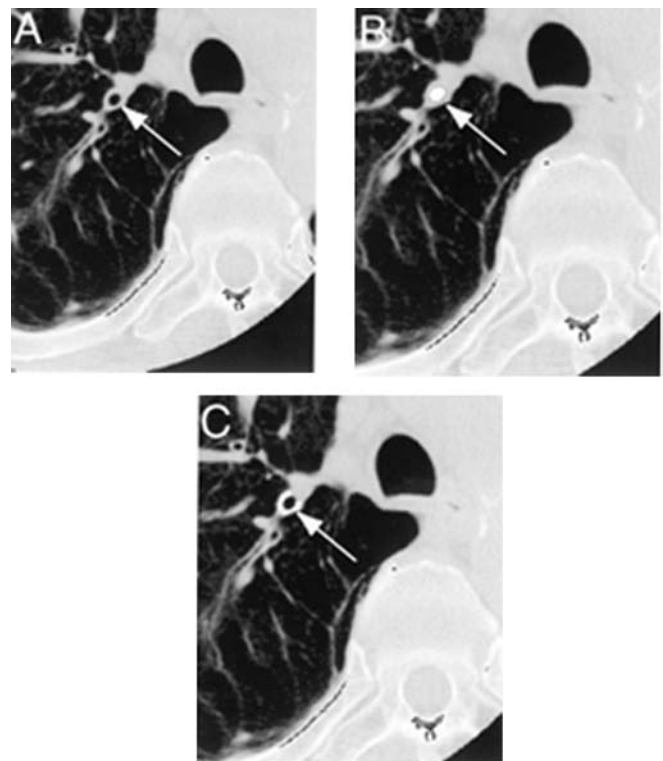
A representative case showing the process of airway analysis. Using a helical CT image containing the apical bronchus to the upper lobe (A), the algorithm defines the luminal area (B) and wall thickness (C). Note that identification of the airway wall thickness was successful even when the pulmonary blood vessel ran parallel to the bronchus.
